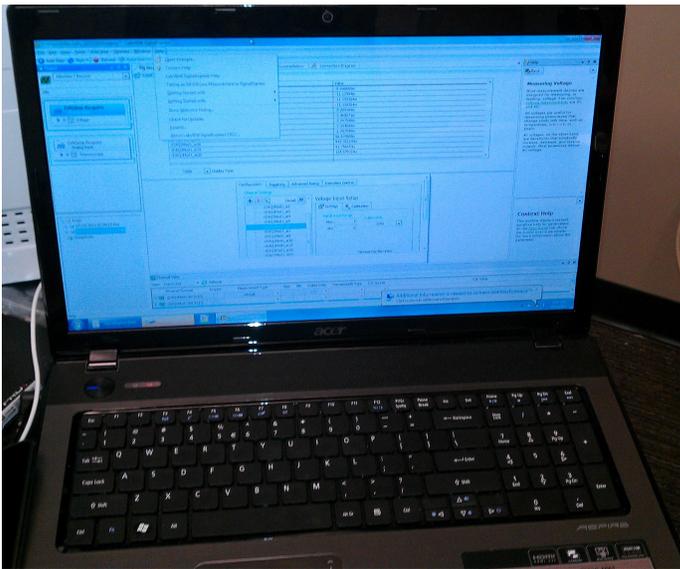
Acer PC collecting data from Moor Laser Doppler Flowmetry probes using Labview Data Express
